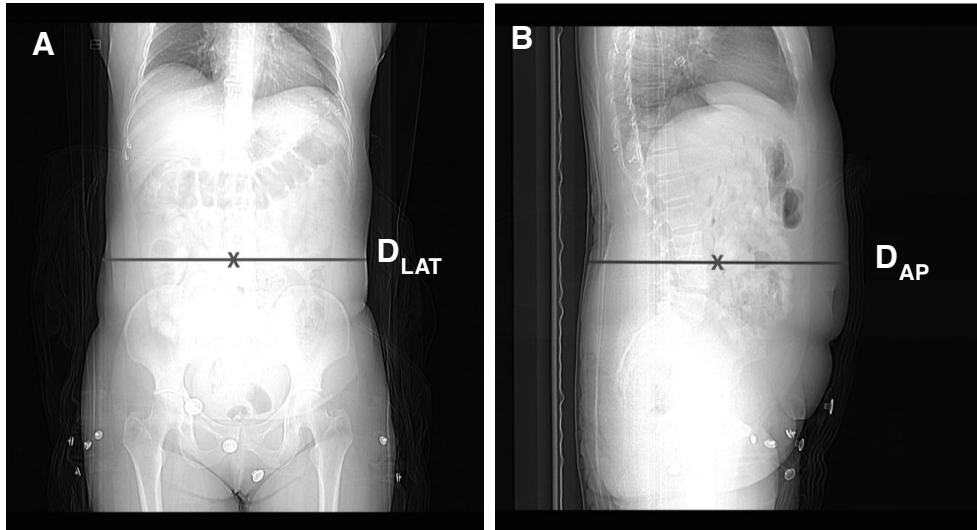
Measurement of patient diameters. A-B: measurement of lateral (D_{LAT}) and antero-posterior (D_{AP}) skin-to-skin diameters at the midslice level on the CT localiser images. The X indicates the midpoint of the midslice diameter.
